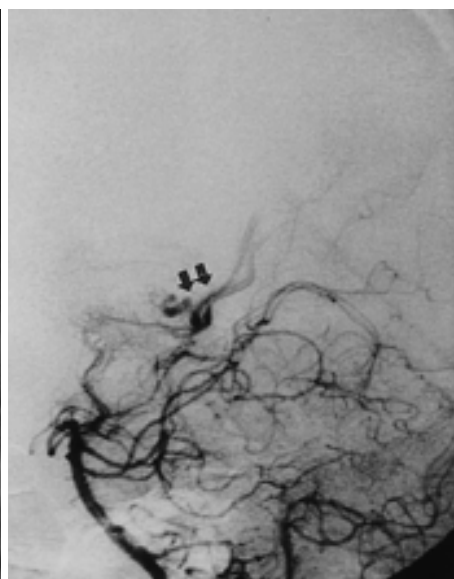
Thalamic AVM(A) was changed to decreased signal void lesion and increased nodular enhancing portion in follow-up MR images of 27 months after radiosurgery(B). But linear signal void lesion (arrow) was remained. Initial vertebral angiography(C) showed dilated arterial feeder, tangled vascular structures of nidus and arteriovenous shunting indicating brain AVM. Follow-up vertebral angiography(D) obtained in 27 months after radiosurgery showed still arteriovenous shunting (arrows) without abnormal tangled vessels.
